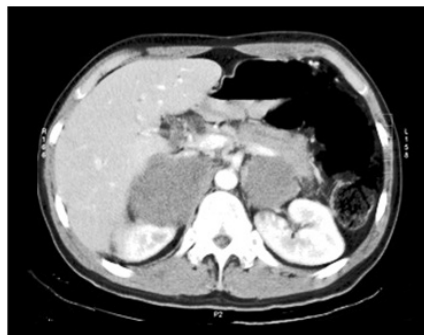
Computed tomography images of the abdomen revealed a hypo dense mass in the right sub diaphragmatic area , superior to the right kidney which was suggestive of an" adrenal tumor " with adjacent hepatic involvement.
